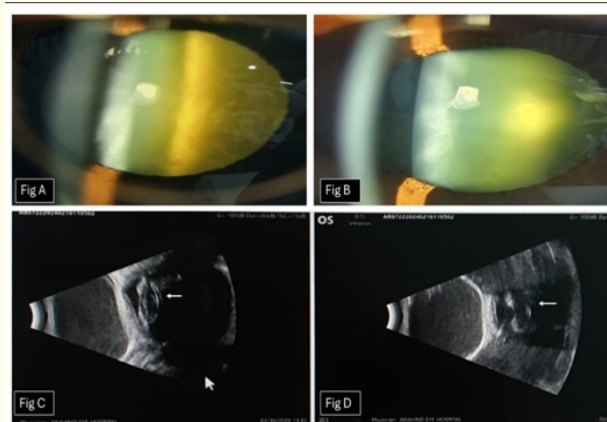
Anterior segment examination showed yellowish-white reflex in RE in posterior aspect of lens (?doubtful) in anterior vitreous face (AVF) (Figure 1A), minimal cortical changes in LE (Figure 1B). Fundus was faintly seen in right eye and left eye was normal. On ultrasound B scan stand-off image, RE showed posterior capsular limit with few cortical calcification [white arrow] (Figure 1C), LE posterior capsule was not clearly distinguished [white arrow] (Figure 1D).
